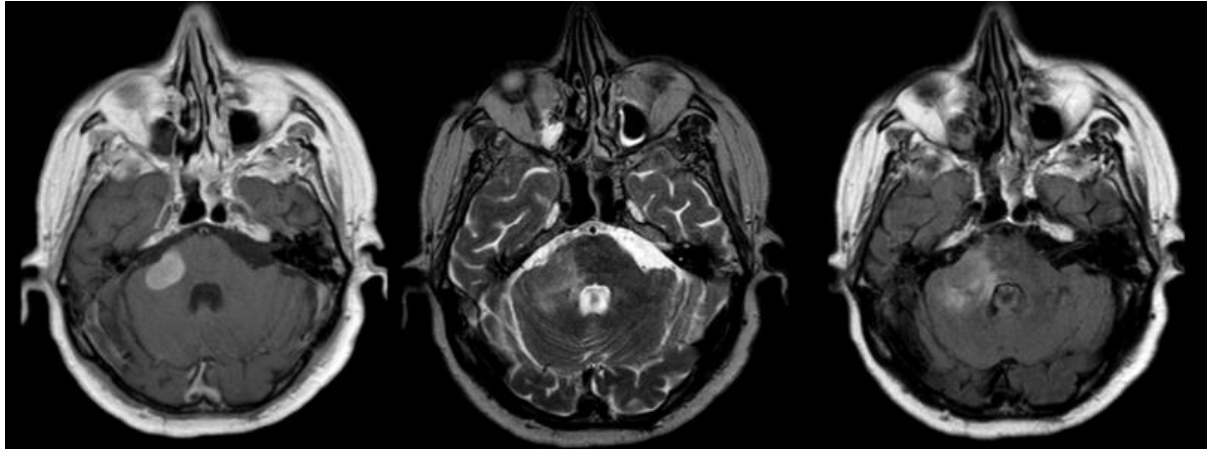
T1, T2, FLAIR MRI scans in PCNSL
